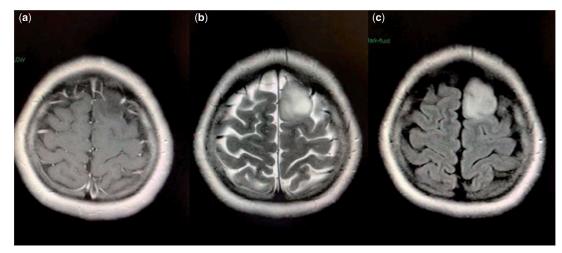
(a, b, c) Preoperative axial flair (a), T2W (b) and contrasted T1W (c) MRI shows left frontal contrast enhancing lesion.
